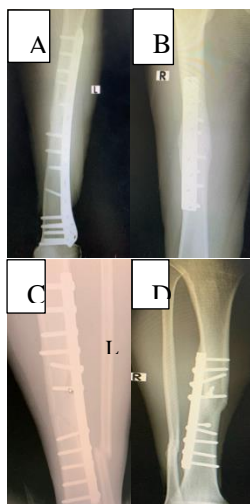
The radiographs revealed bone union of bilateral femoral (A,B) and tibial (C,D) fracture sites at postoperative 13 months.
